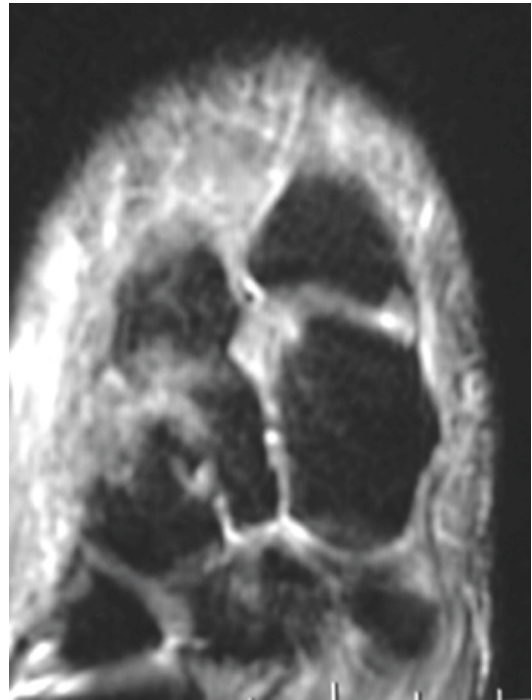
Coronal images fluid-sensitive MRI sequencing demonstrating disruption of the Lisfranc ligament complex
